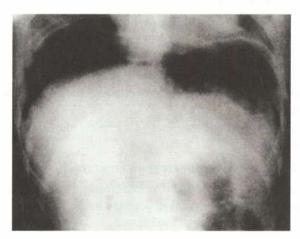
Plain X-ray abdomen showing collection of free gas under the right dome of the diaphragm
